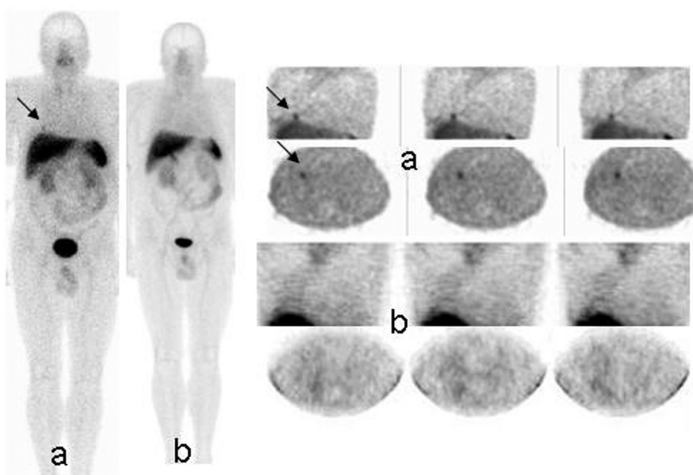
a) Enhanced uptake of ^{99m}Tc -EDDA/HYNIC-TOC on whole body scintigraphy and SPECT in a patient with NET in the right lower lobe, diameter 2.2cm (arrow). b) No uptake after surgery. Ki-67 = 0%.
